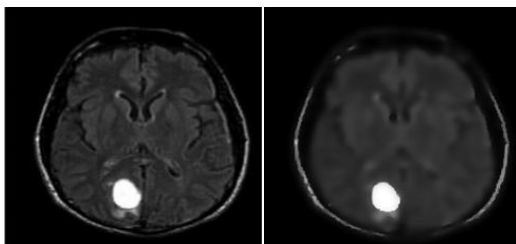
a: MRI Image Fig.6.b Anisotropic diffusion filter
